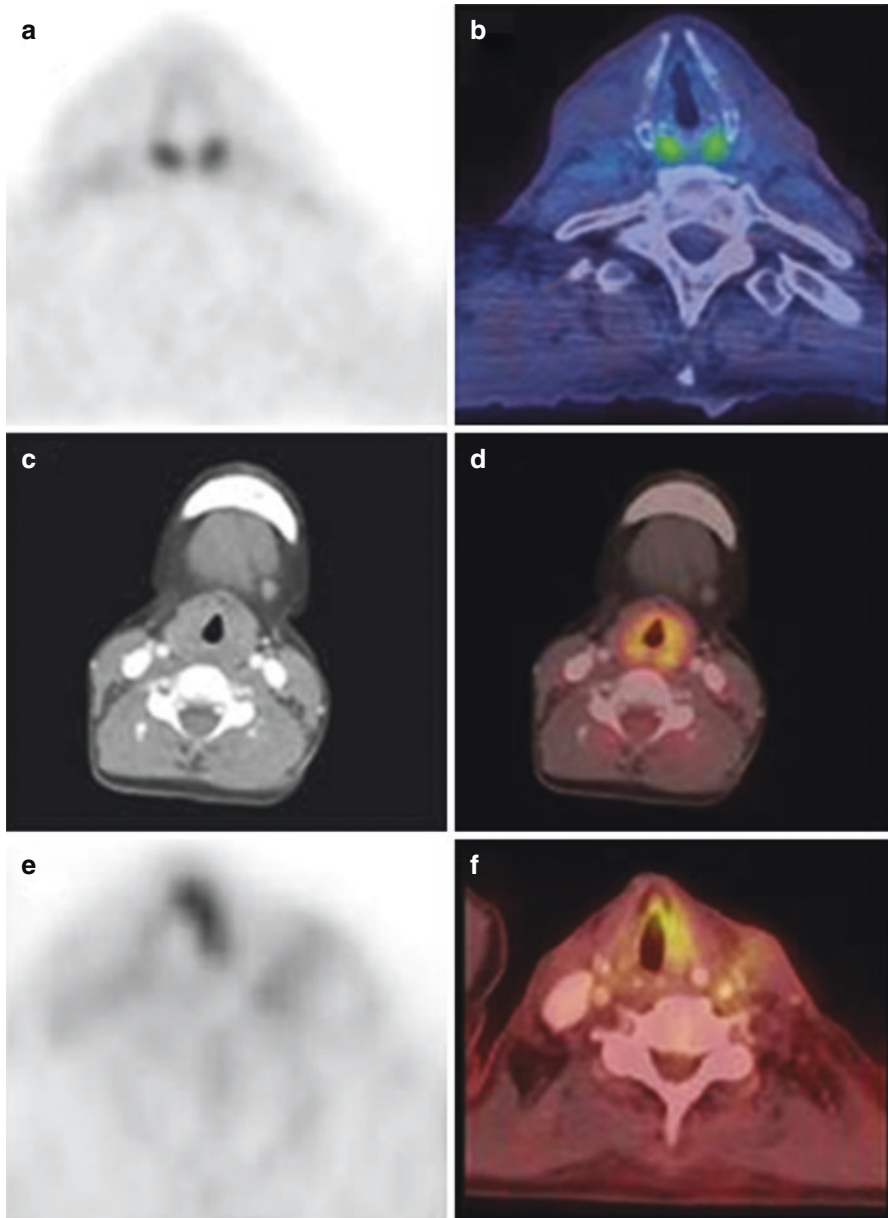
(a, b) axial ^{18}F -FDG PET and fused PET/CT images show symmetrically increased tracer uptake in the arytenoid muscles. (c, d) axial CT and fused ^{18}F -FDG PET/CT images show symmetrically increased tracer uptake in the laryngeal muscles. [This should be minimised in patients with head and neck cancer by maintaining silence after tracer injection]. (e, f) Axial ^{18}F -FDG PET and fused PET/CT images show asymmetrical increased tracer uptake in the left vocal cord due to recurrent laryngeal nerve palsy on the right side. [When there is asymmetrical uptake in the vocal cords, it is the normal vocal cord that demonstrates increased uptake and the side with no increased uptake is the side with the nerve palsy]
